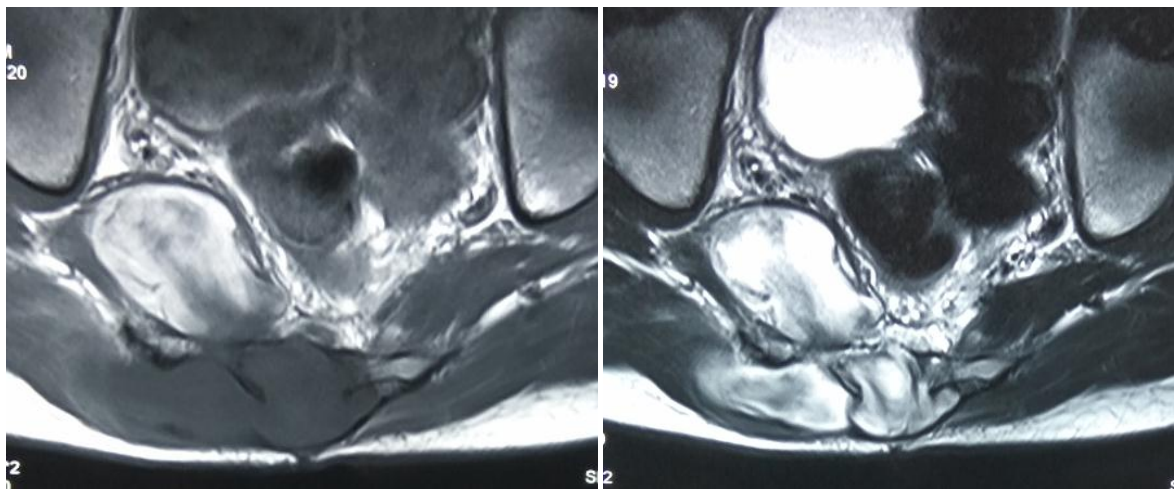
Axial MRI (T1W and T2W image with contrast) showing sacral mass with anterior extension to presacral space and right piriformis muscle involvement
